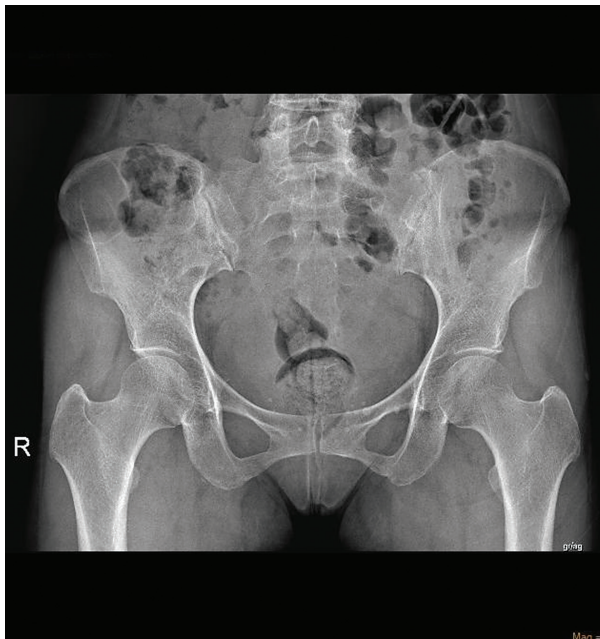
Plain radiograph of Case 1 showing normal sacroiliac joints.
